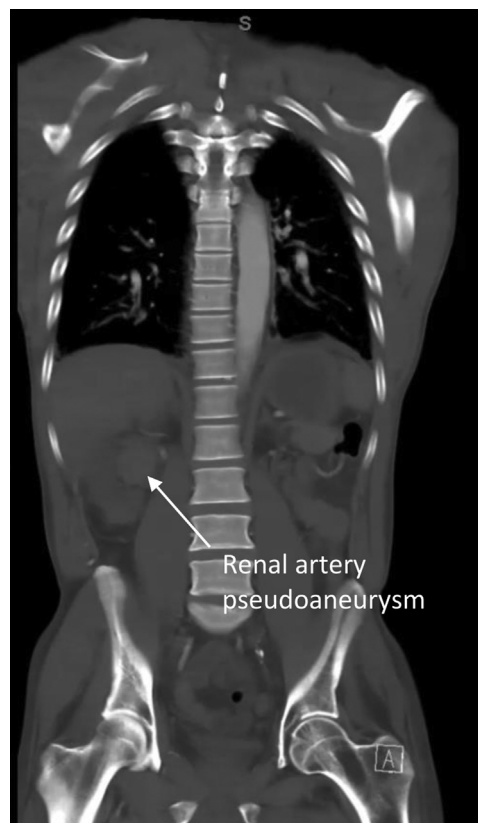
Computed tomography scan showing right renal artery pseudoaneurysm (arrow) and right kidney.
